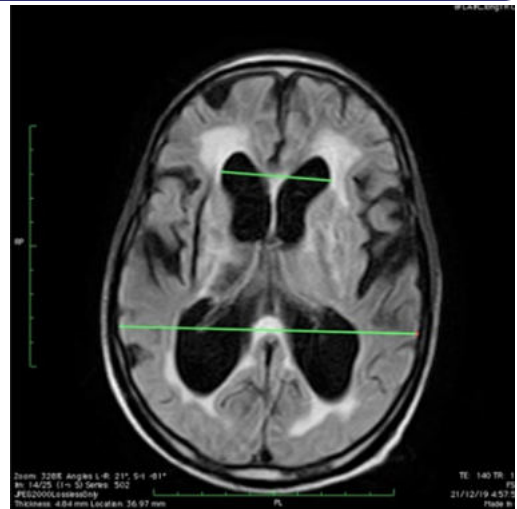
Axial FLAIR image shows measurement of Evan's index.
